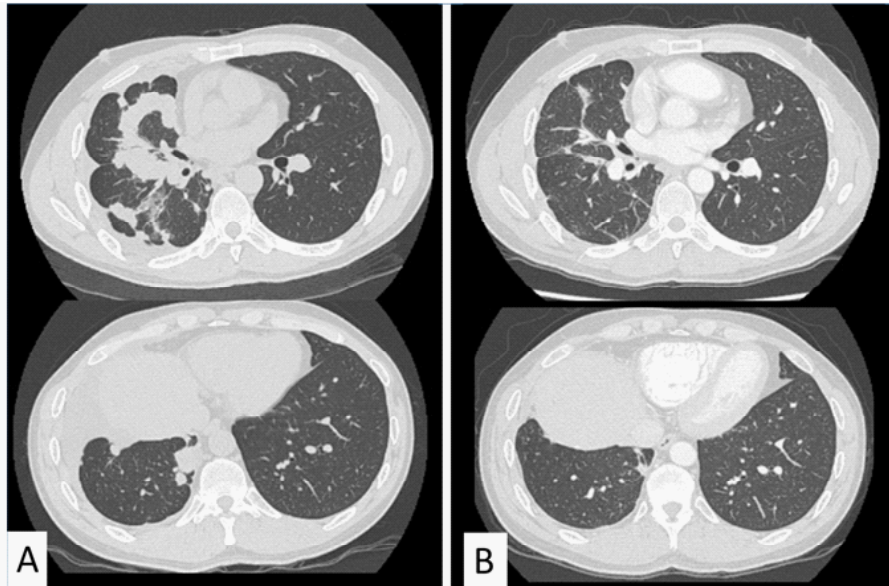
(A) The chest computed tomography imaging revealed formation of ring-shaped nodules on the right parietal pleura without any apparent intrapulmonary nodules. (B) Alectinib chemotherapy induced a dramatic response in the case.
